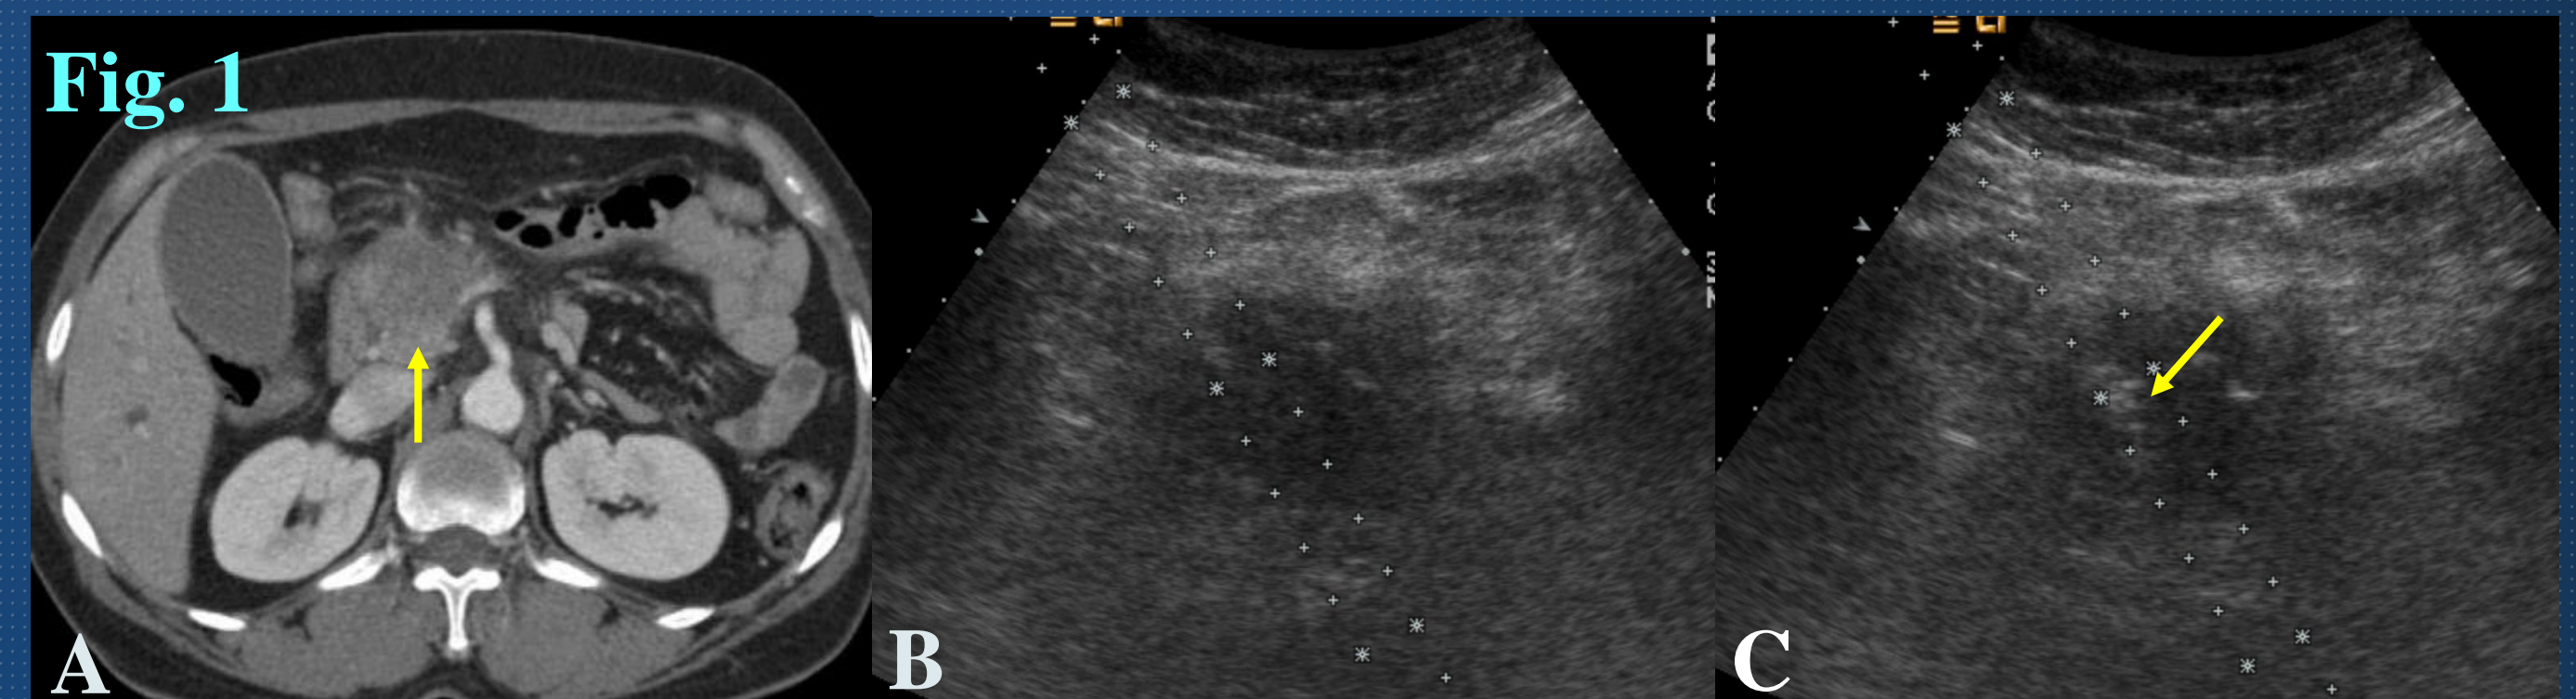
A 66-year-old female patient with pancreas cancer (A) CT image shows hypovascular mass in pancreas head. Transverse sonogram shows a hypoechoic mass in the head of the pancreas. Pre-firing(B) and post-firing(C) sonogram shows the echogenic needle in the mass (yellow arrow).
